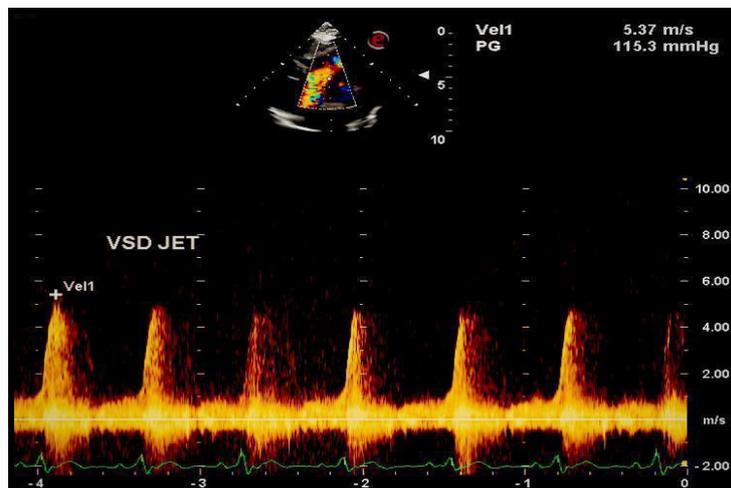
CW Doppler flow across AMB:
